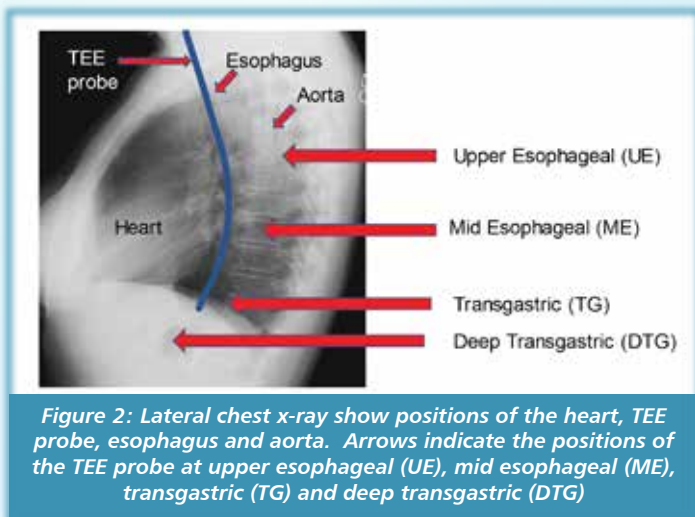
Transesophageal Echocardiography Probe
